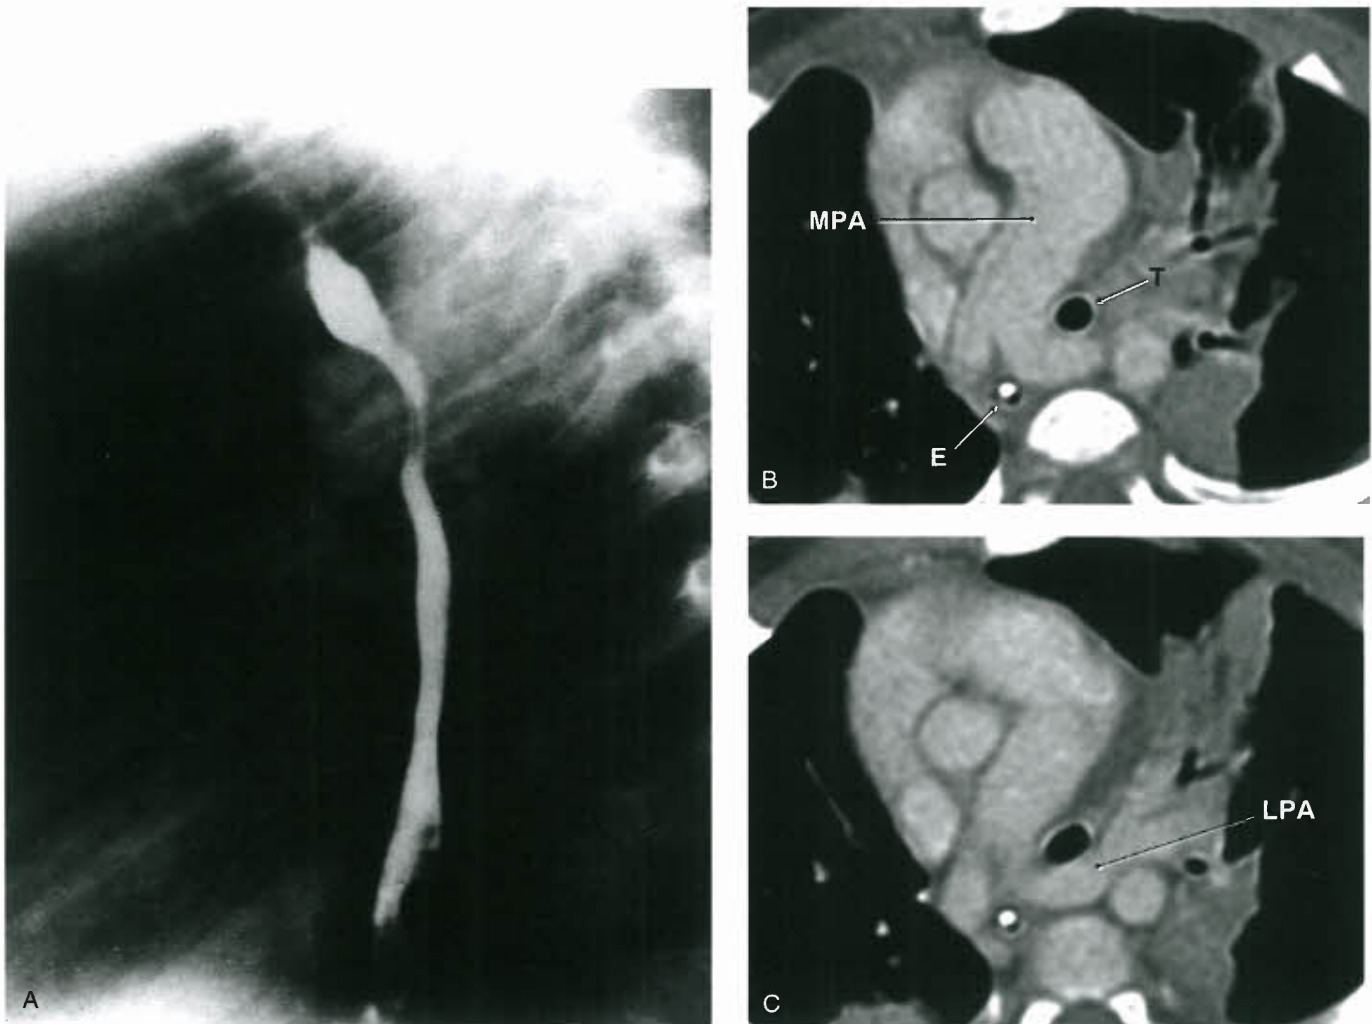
Anomalous origin of left pulmonary artery from RPA (sling). A: Barium esophagram showing classical anterior indentation. B,C: Consecutive images from CT scan of another patient, showing left pulmonary artery (LPA) looping around a small distal trachea (T) but anterior to the esophagus (E) with high signal from a nasogastric tube. (*Continued*)
